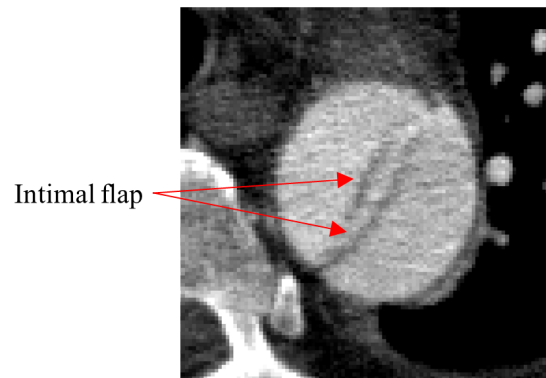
Motion artefact visible due to flap motion on the axial view of the descending aorta on the CT scan for P2. Red arrows indicate the intimal flap (darker line in the middle of the aorta).
